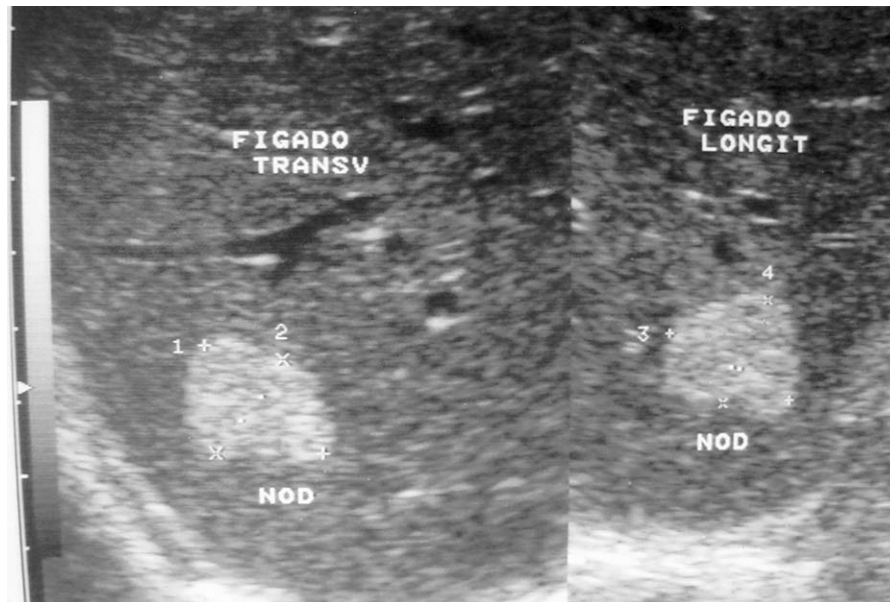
Liver ultrasound showing a small (1.2 cm in diameter) homogeneous, hyperechoic well-delimited nodule.
